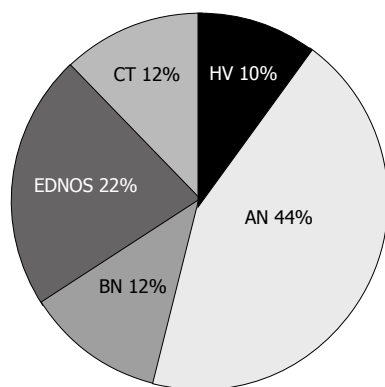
Distribution of the postprandial distress syndrome diagnosis in anorexia nervosa, bulimia nervosa, eating disorders not otherwise specified, constitutional thinners and healthy volunteers ($n = 41$). AN: Anorexia nervosa; BN: Bulimia nervosa; EDNOS: Eating disorders not otherwise specified; CT: Constitutional thinners; HV: Healthy volunteers.
